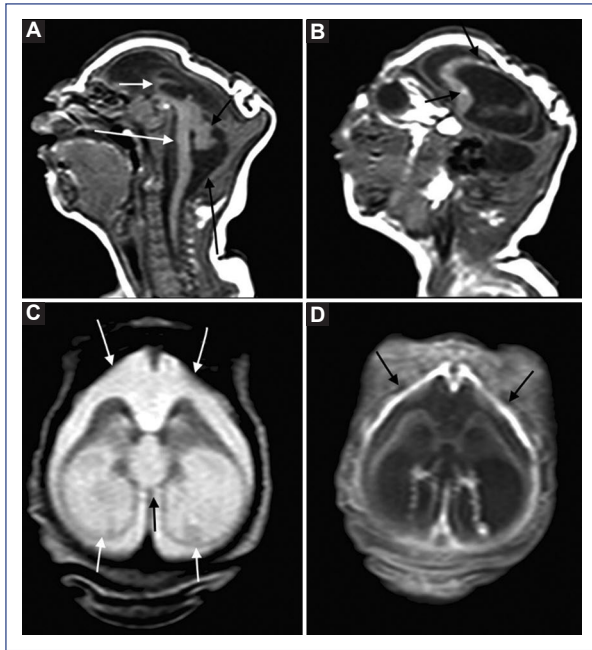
CT scan of newborn with severe microcephaly. A: profound craniofacial disproportion, corpus callosum (short white arrow), brainstem (long white arrow) and cerebellar hypoplasia (short black arrow), enlarged cisterna magna (long black arrow). B: calcifications in frontal lobe. C: severe ventriculomegaly. D: increased thickness of pachymeninges. Image obtained from de Fatima Vasco Aragao et al.⁶⁸.
